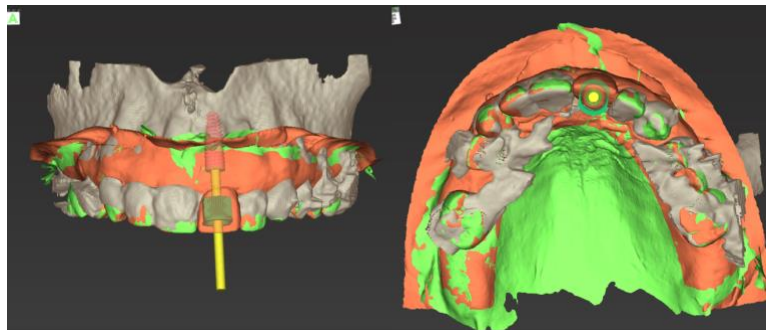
Superimposition of three scanned files, patient's preoperative CBCT scan image (DICOM), patient's preoperative intraoral scanned image (STL), and wax-up cast scanned image (STL)
